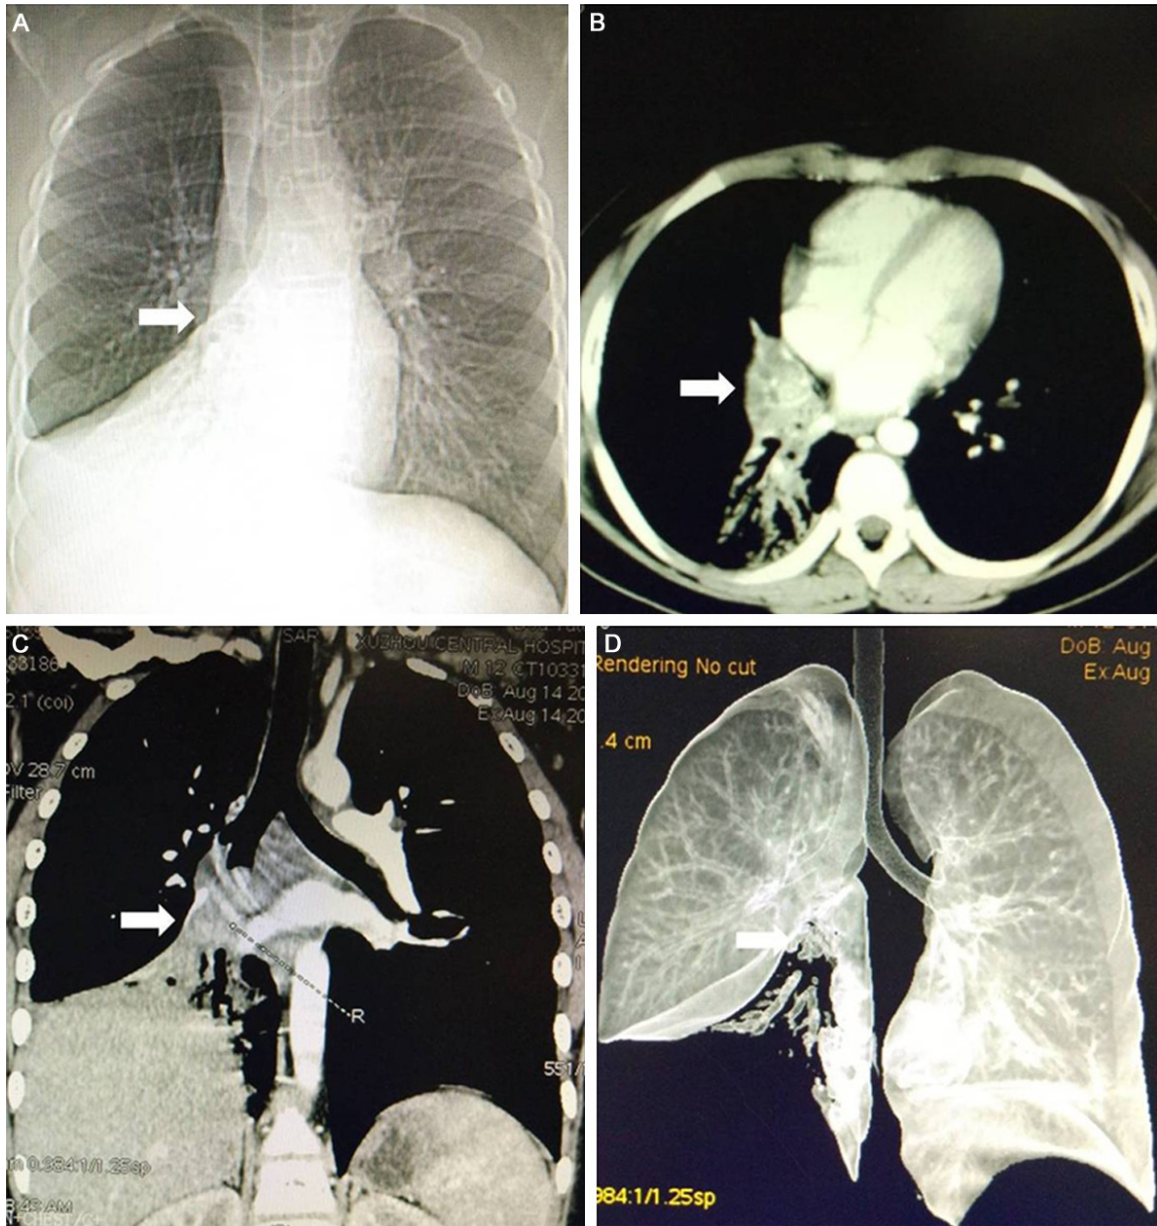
Chest X-ray and CT of the patient on admission revealed an intraluminal lesion in the right main bronchus, with atelectasis of the right middle and lower lobes.
